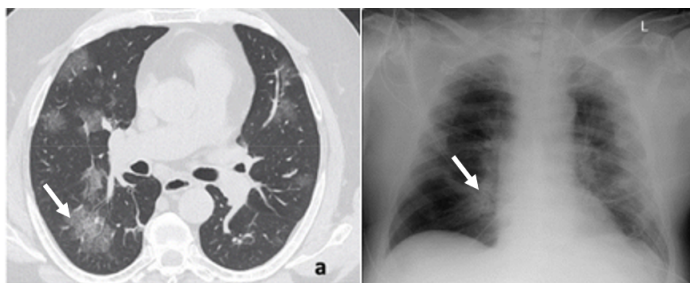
Comparison of COVID-19 glass-opacity in CT scan (left) and X-ray (right). Left image from Caruso et al. [16] right image from actual data set
